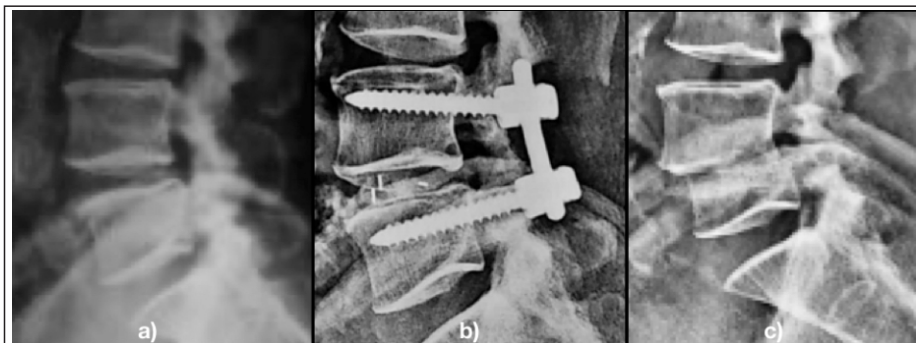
a) Preoperative X-ray, b) after a wound wash with implants in situ, c) collapse of the disc after implant removal
